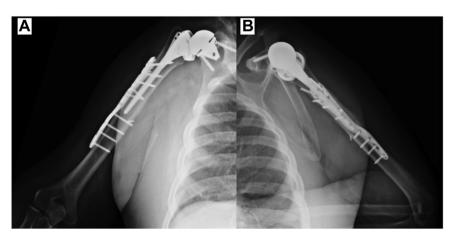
Final follow-up x-rays with advanced consolidation in both anteroposterior (A) and lateral (B) views.
